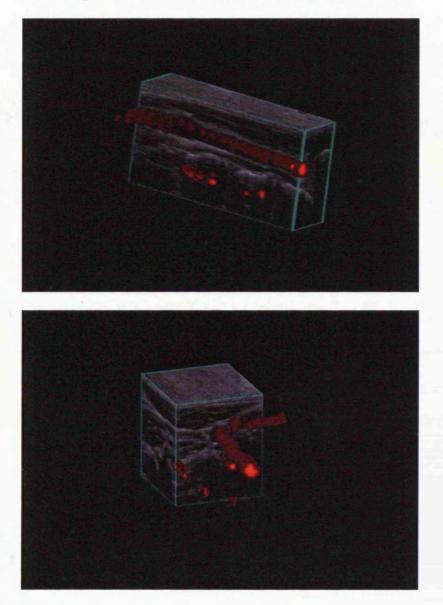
Examples of the ultrasound machine reconstructed 3D volume showing different cut planes through the volume.
